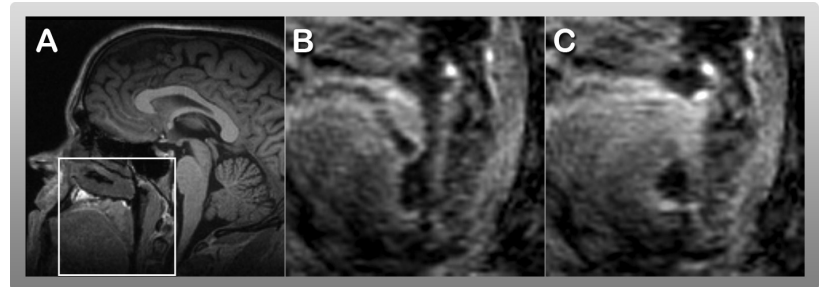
(a) T1-weighted anatomical scan. (b) Real-time MRI images with reduced FOV (outlined in a) of a bolus being transferred from oral to pharyngeal stage and (c) initial contact of the velum (soft palate) with the posterior pharyngeal wall.
